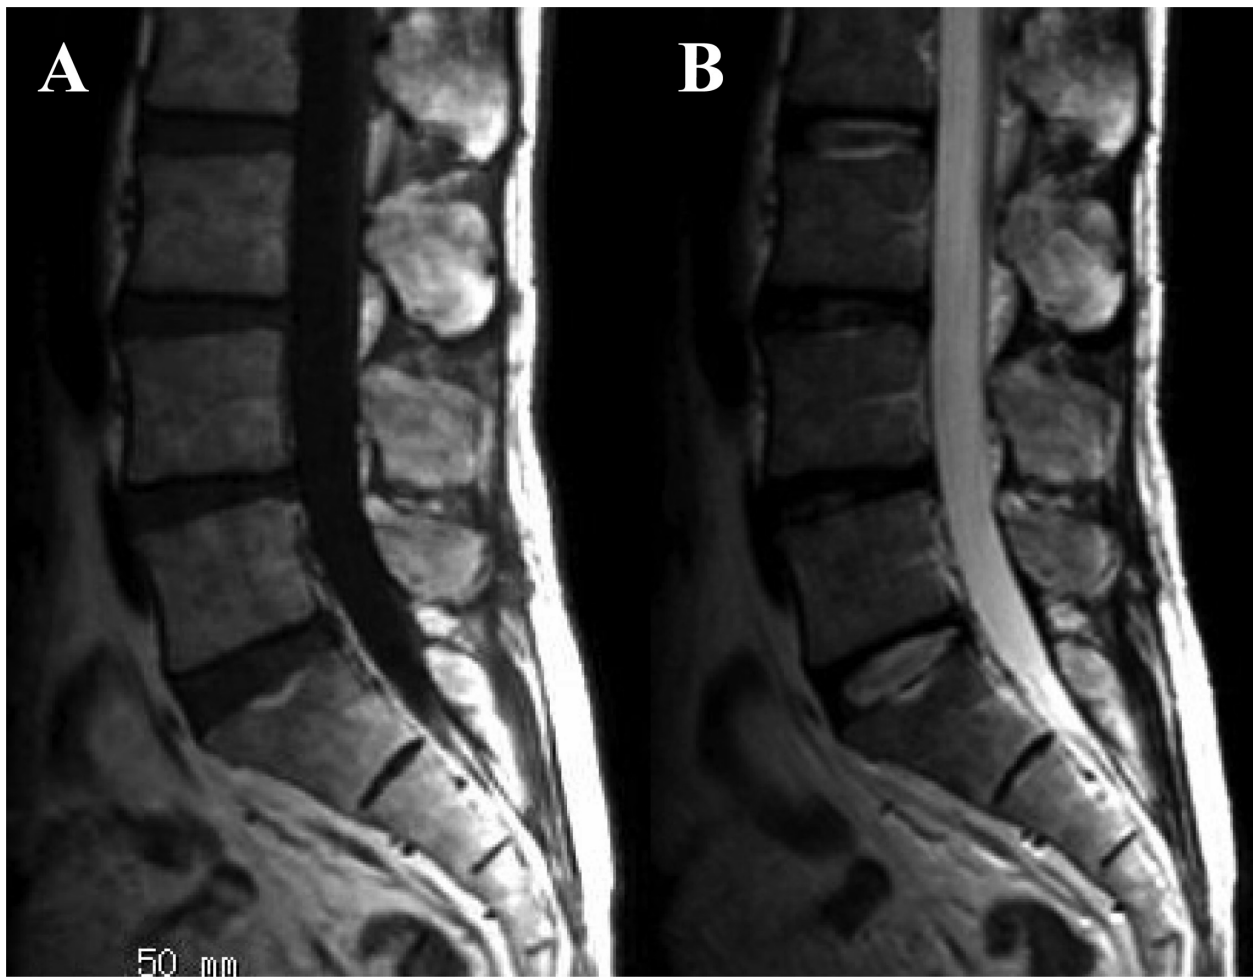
MRI scans of the lumbar spine. A) A T1-weighted image. B) A T2-weighted image. MRI studies showed abnormal high intensity in the interspinous region.
